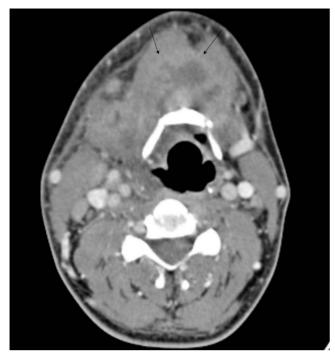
Axial contrast-enhanced CT showing an ill-defined phlegmon/abscess (black arrows) in the floor of mouth with an odontogenic source identified in the mandible.
